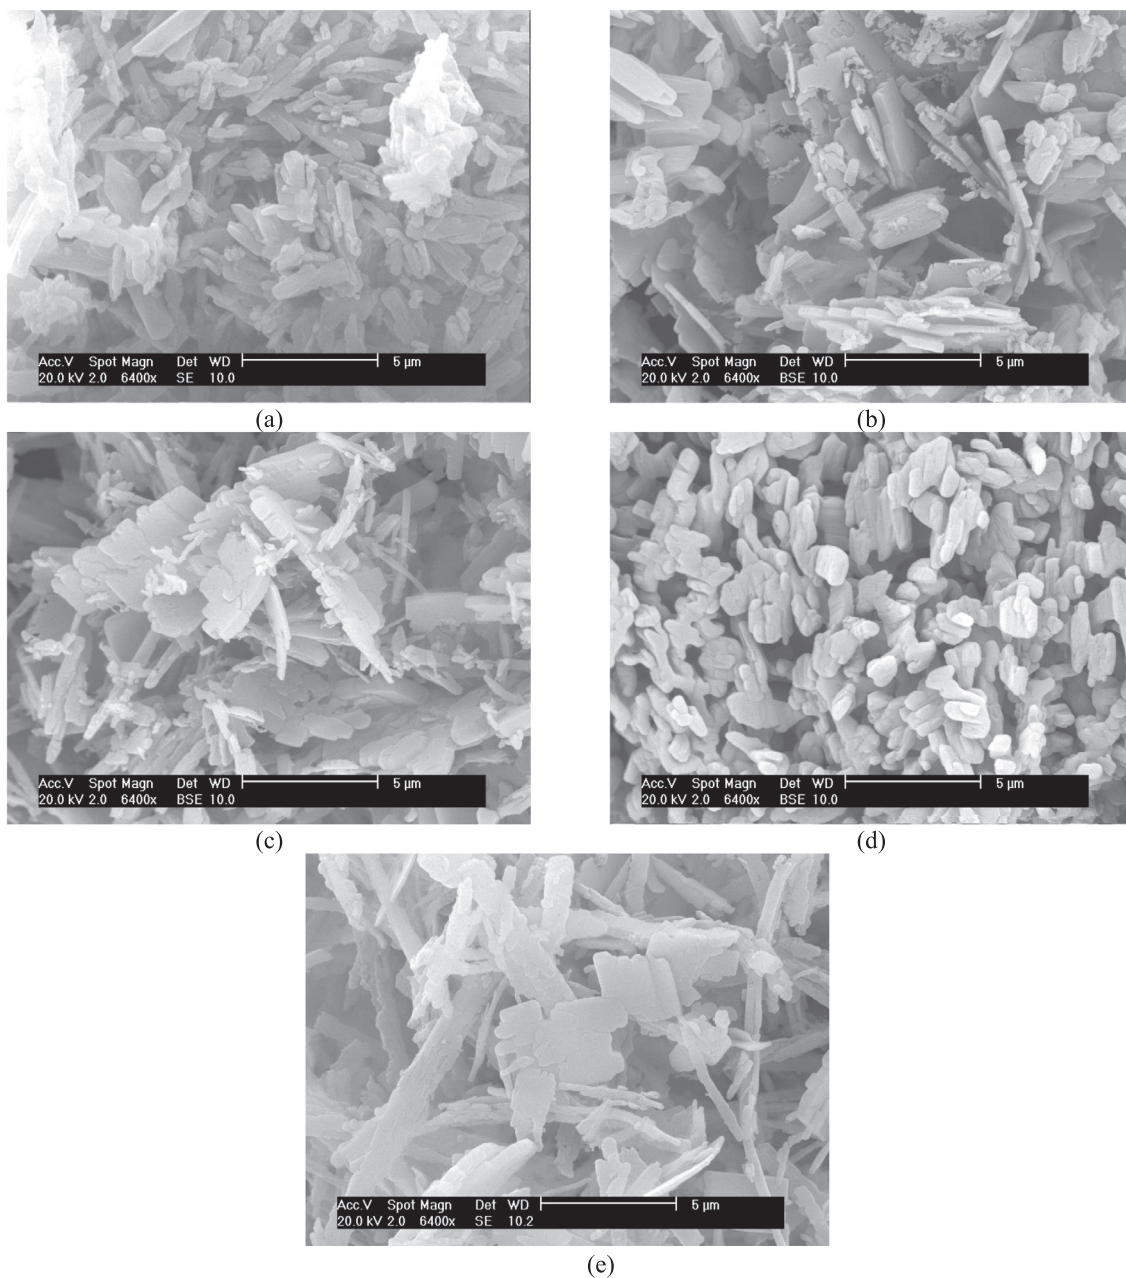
SEM images of the recrystallized LASSBio-294 by dropwise addition. (a) 40 W, experiment 10; (b) 30 W, experiment 13; (c) 20 W, experiment 14; (d) 10 W, experiment 15 and (e) 0 W, experiment 9 (without ultrasound).
